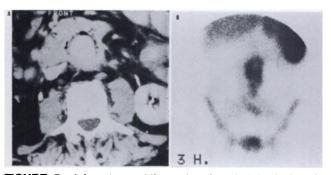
Infected aorto-bifemoral graft and abdominal aortic perigraft abscess (*E. coli* and kebsiella pneumoniae). (A) CT shows soft-tissue density mass and small gas pockets in the graft bed. (B) Technetium-99m-HMPAO leukocyte scan demonstrates increased uptake in the region of the aortic graft.
